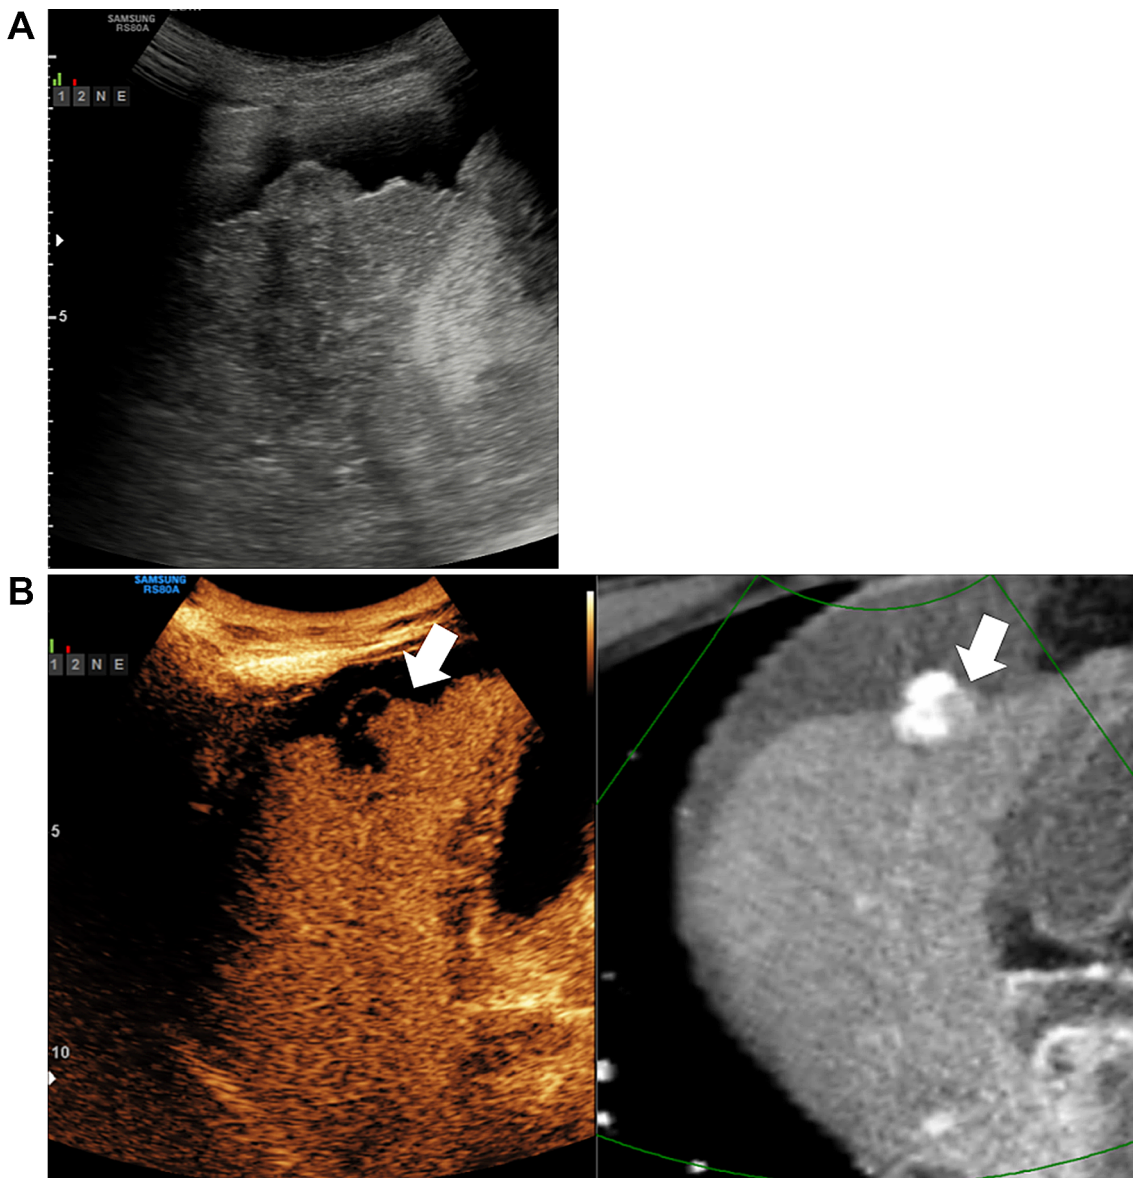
A 61-year-old male with history of multisession TACE for HCC. On CT image, there was suspicious marginal recurrence on segment 5 lipiodolized nodule (B, white arrow).
